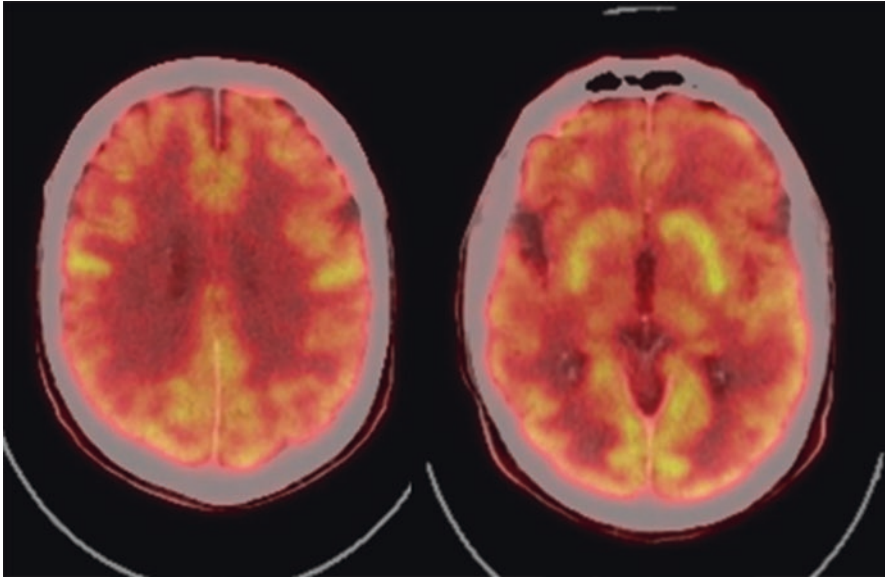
PET-CT ^{18}F -FDG showed diffuse supratentorial cortical hypometabolism (left), also in cerebellum, basal ganglia and thalamus (right)
